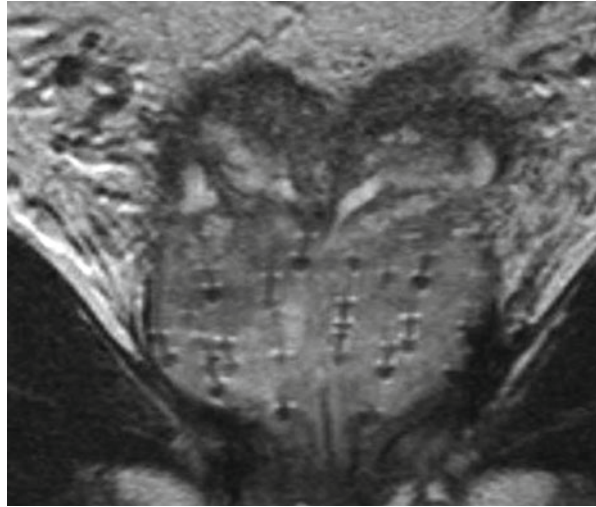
Axial CT-MRI fused image
